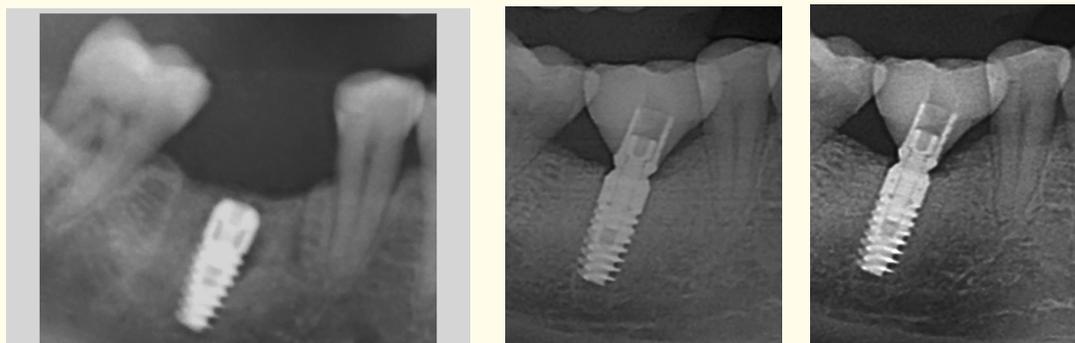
Radiographic images of patient 15. (A) X-ray image of the implant placed immediately after extraction of tooth 36. (B) X-ray image of dental implant regio 36 one year after prosthetic rehabilitation. The bone level reaches the implant shoulder. (C) X-ray image of dental implant regio 36 at the 2-year follow up investigation. The peri-implant bone level is stable and no peri-implant osteolysis or bone resorption could be detected.
